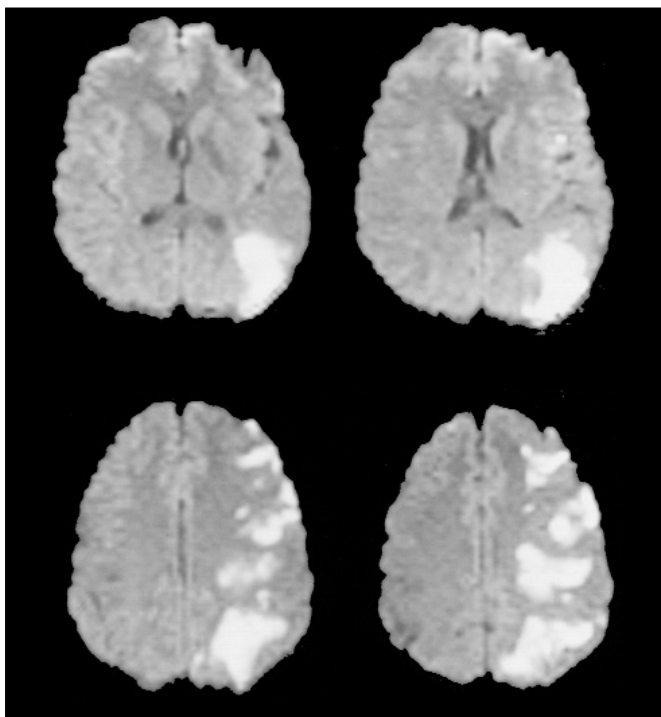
Diffusion-weighted magnetic resonance imaging at presentation showing acute frontal, temporal and parietal infarctions, estimated at less than one-third of the middle cerebral artery territory. By convention, the right hemisphere is at left and the left hemisphere is at right.
